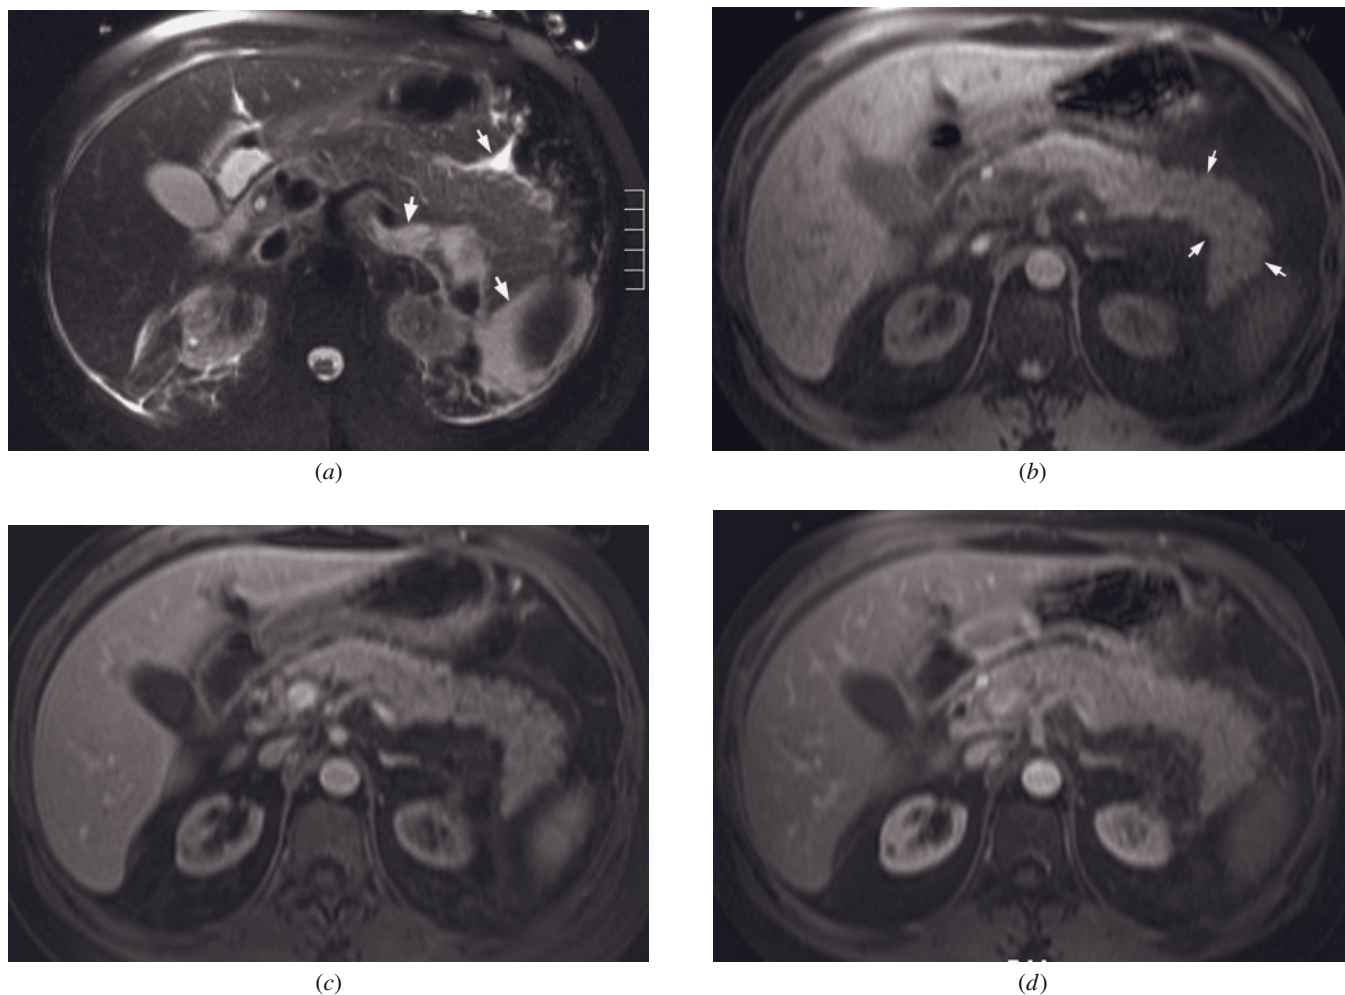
Autoimmune pancreatitis. Fat-suppressed T2-weighted SS-ETSE (*a*), fat-suppressed T1-weighted gradient-echo (*b*), and immediate (*c*) and interstitial-phase (*d*) postgadolinium fat-suppressed T1-weighted images in a patient with autoimmune pancreatitis demonstrate a thin layer of peripancreatic and perisplenic fluid that is best seen on fat-suppressed T2-weighted images (arrows, *a*). The distal body and tail of the pancreas show decreased signal intensity compared to the remainder of the pancreas on fat-suppressed T1-weighted gradient-echo images (arrows, *b*). On immediate postgadolinium image the enhancement of the distal pancreas is less than the proximal portion (*c*). On interstitial-phase image distal pancreas becomes isointense with the rest of the pancreas (*d*).
